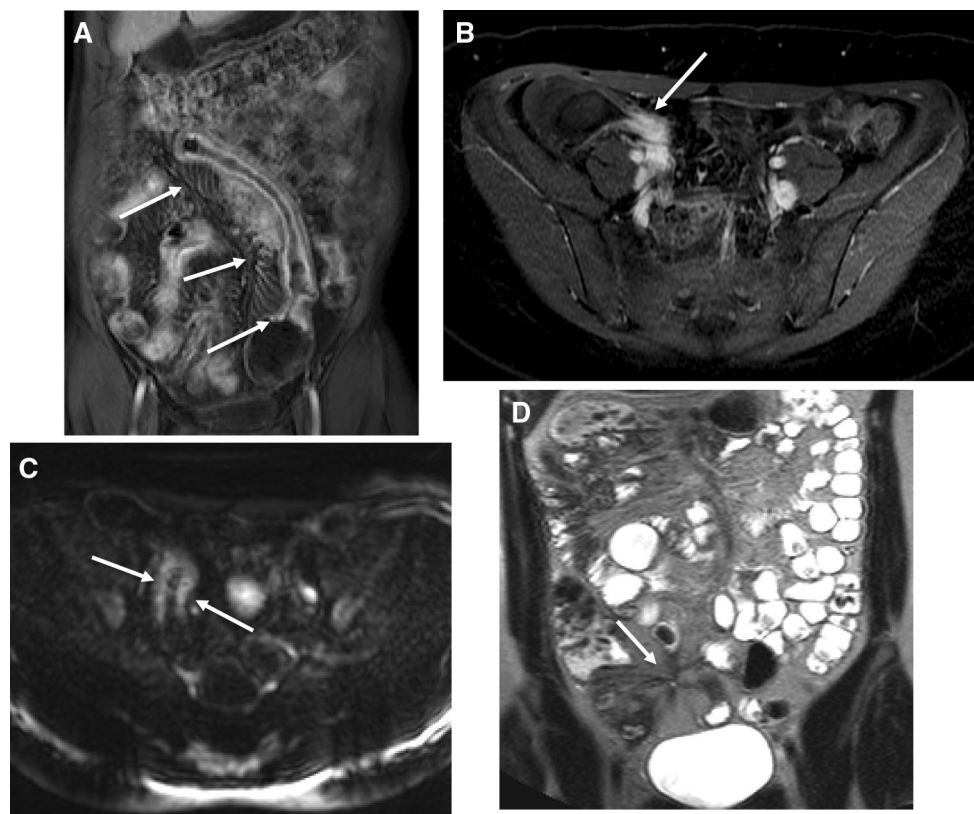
MR enterography in inflammatory bowel disease. The coronal T1-weighted postcontrast image a shows mesenteric vascular congestion—the “comb sign” (arrows)—associated with a thick-walled, hyperemic, acutely inflamed loop of small bowel. Axial T1-weighted postcontrast image in a different patient b with active terminal ileal inflammation shows mural hyperemia (arrow); the corresponding
